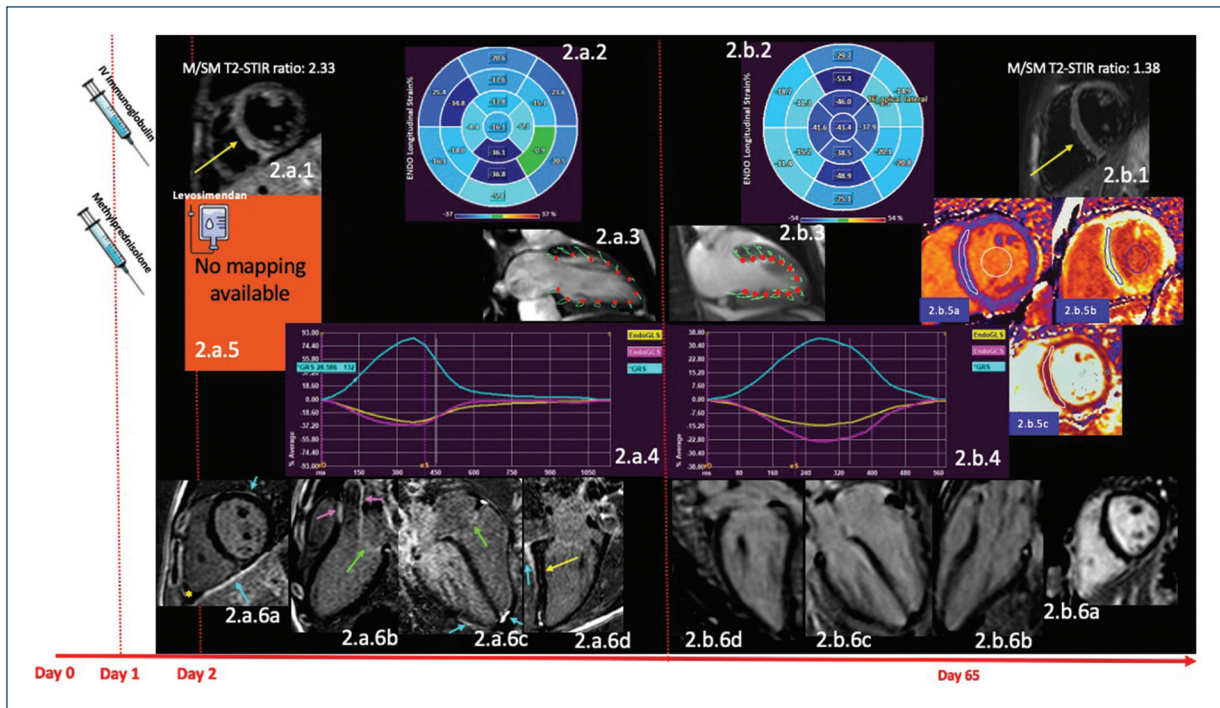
Side-by-side sequences and slice locations comparison of the two CMR studies. Comparison of the first CMR (2.a) study performed on day 1 of hospitalization and the follow-up CMR (2.b). 2.a.1 shows a T2-weighted STIR sequence in short-axis view of the mid ventricle where the yellow arrow highlights the areas of increased signal intensity in the interventricular septum and a myocardium/skeletal muscle ratio of 2.33 corresponding to myocardial edema, that on its corresponding follow-up image (2.b.1) shows normal signal intensity with normal myocardium/skeletal muscle ratio suggesting the absence of myocardial edema. Image 2.a.2, 3, and 4 corresponds to the functional and strain analysis showing the regional wall motion abnormalities and the reduced LV global function with a global strain of 29.20%, which on its corresponding follow-up images (2.b.2,3 and 4) shows a normal LV global function with a global strain of 46.49%. Images 2.a.5. corresponds to the mapping techniques, which were not available for the first CMR study. The corresponding images 2.b.5a, b, and c shows the mapping analysis, figure 2.b.5a shows the native T1 of 1071 msec (normal for the 1.5 Tesla magnet used), figure 2.b.5b shows the post-gadolinium map, the extracellular volume obtained was 26% which is normal, figure 2.b.5c shows the T2 mapping with a native T2 value of 48 msec (normal for the 1.5 Tesla magnet used). At the bottom of the figure, images 2a.6 and 2b.6 show the late gadolinium-enhanced T1-weighted inversion-recovery with phase-sensitive reconstruction algorithm sequences, 2.a.6a is the short-axis view at mid ventricle, 2.a.6b, is the 3-chambers view, 2.a.6c is the 4-chambers view, and the 2.a.6d is the two-chamber view of the first CMR to the left side of the figure, which shows linear intramural and patchy enhancement areas in different locations in the myocardium, as is marked by the yellow arrow in image 2.a.6d, as well as enhancement of the valves (green arrows) and ascending aorta in image 2.a.6b (pink arrows), and the enhancement of the pericardium (blue arrows) with mild pericardial effusion (yellow asterisk). To the right side of figure, the corresponding images and locations of the second study at day 65 of follow-up (images 2.b.6a, 2.b.6b, 2.b.6c, and 2.b.6d) that show no myocardial, valvular, aortic, or pericardial enhancement and no pericardial effusion. M/SM: myocardium/skeletal muscle; T2-STIR: t2-weighted with Short Tau Inversion Recovery; LV: left ventricular.
